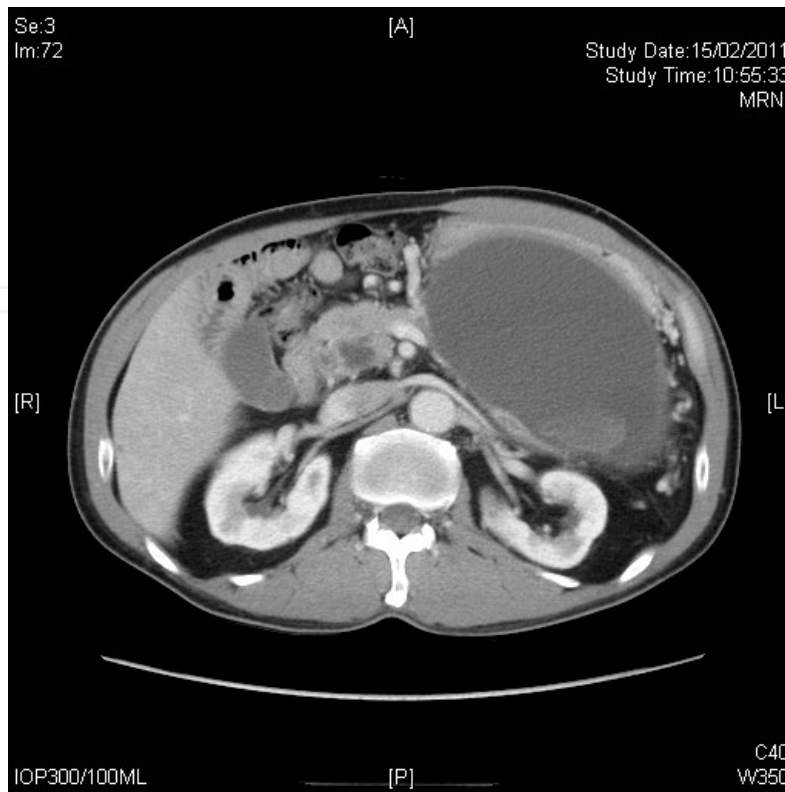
CT film demonstrating the presence of an 8cm pseudocyst located at the pancreatic tail region.
